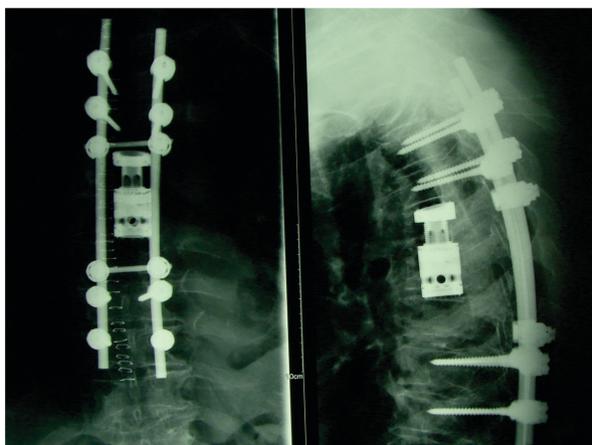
Postoperative CT of a Patient after Vertebrectomy of the 5th and 6th Segments of the Thoracic Spine, Cage Insert and Fixation with the Universal Spine System between the 2nd and 9th Segments of the Thoracic Spine (coronal and Sagittal View).
